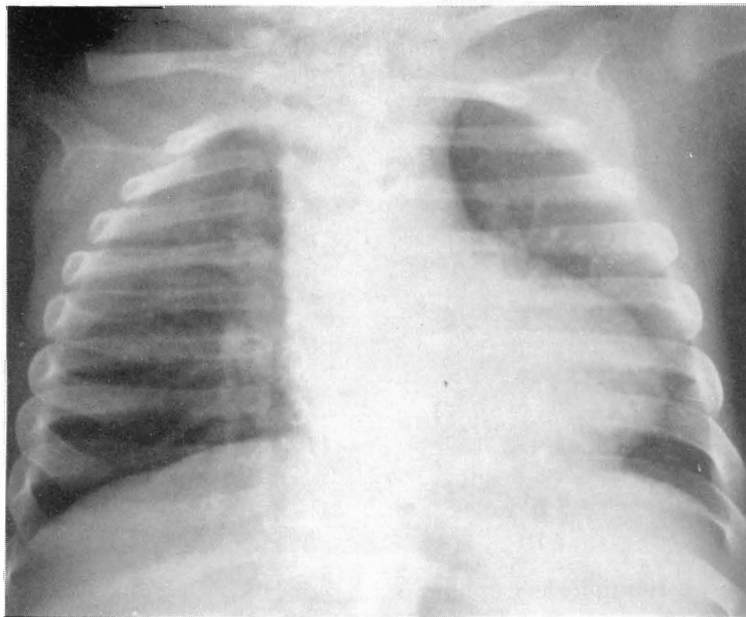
Chest X-ray findings
